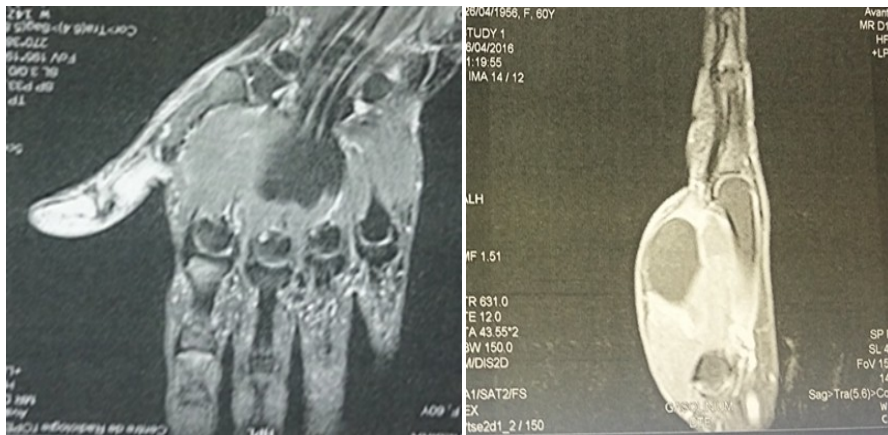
Giant lipoma of the hand on MRI.
